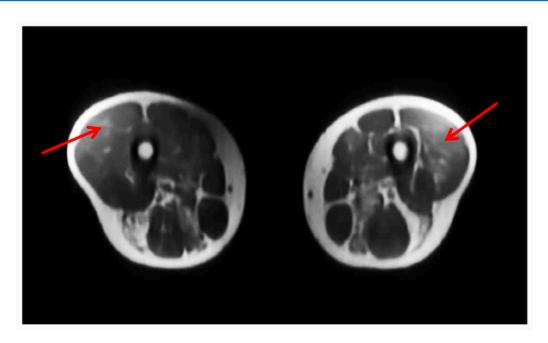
MRI evaluation in lower limbs. After MCT oil treatment, muscle MRI highlighted advanced fat and connective tissue substitution (arrows) in both lower extremities
